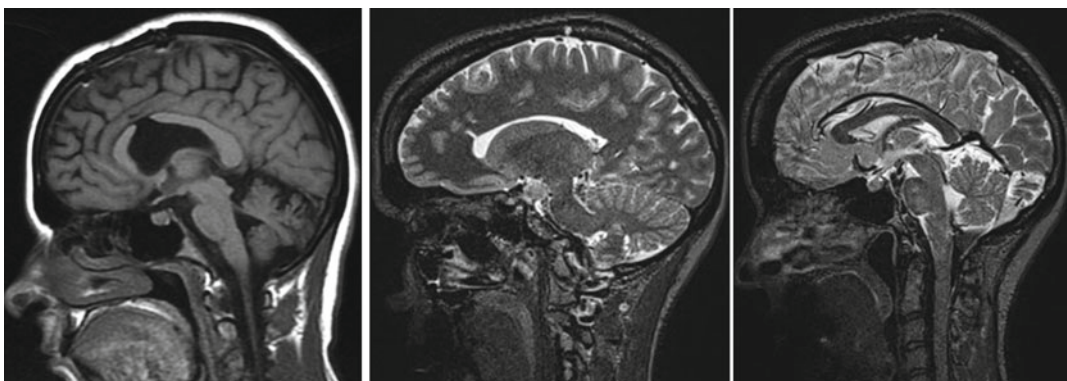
Postoperative sagittal MR images of patients who had colloid cysts of the third ventricle removed with transcallosal approach (*left*) and endoscopic approach (*middle* and *right*)
